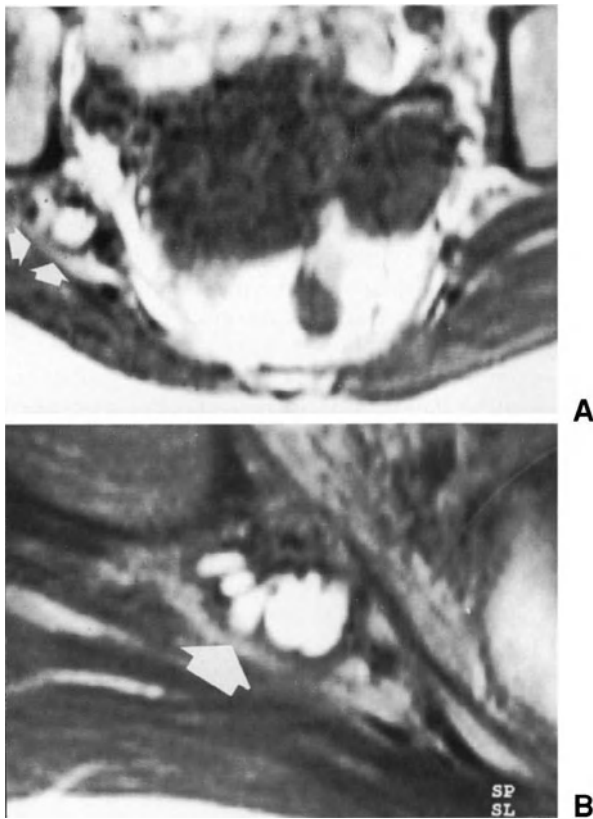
Endometriosis of the sciatic nerve. (A) Axial T2-weighted spin-echo MRI image after injection of gadolinium. A hyperintense mass, 2 cm in diameter, is present at the level of the right sciatic notch (arrow). (B) Axial T2-weighted MRI image at higher magnification. The arrow indicates the endometriosis.
